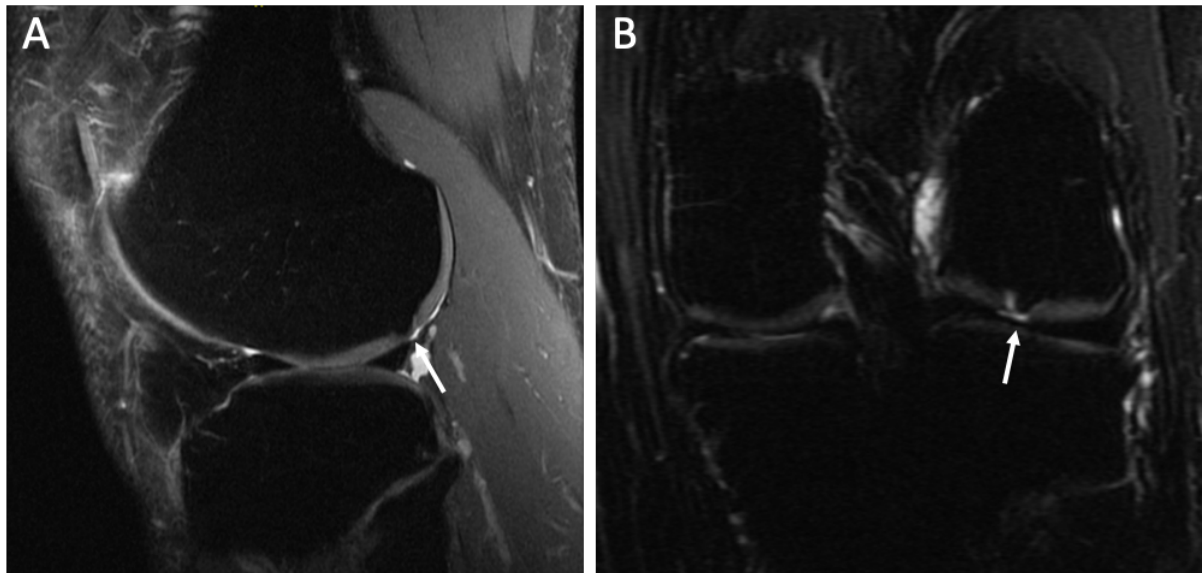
Magnetic resonance imaging (3 Tesla) of an intralesional osteophyte after prior failed microfracture. Sagittal (A) and coronal (B) fat-suppressed intermediate-weighted images demonstrating an intralesional osteophyte after prior failed microfracture.⁵³
